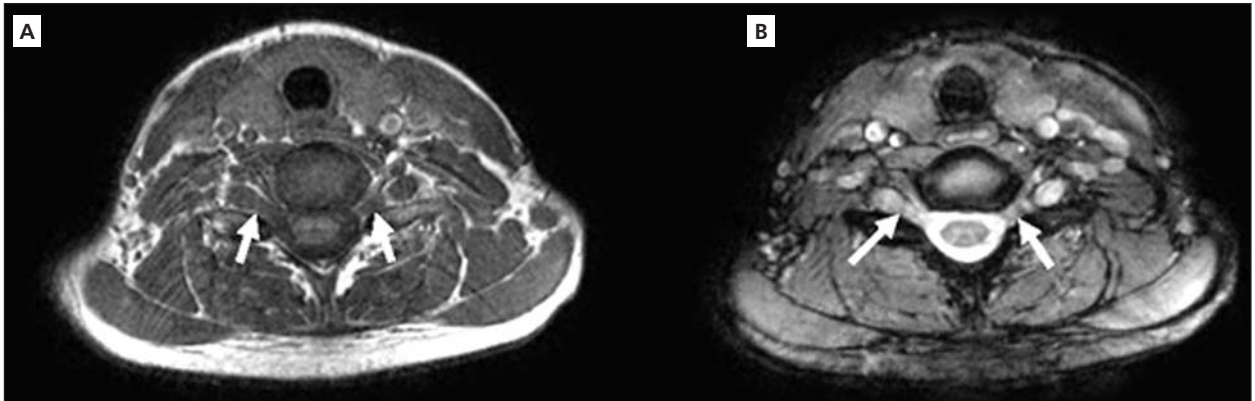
Axial T1-weighted image (A) and T2-weighted image (B) through the cervical spine show symmetric marked hypertrophy of spinal nerve roots (arrows).
